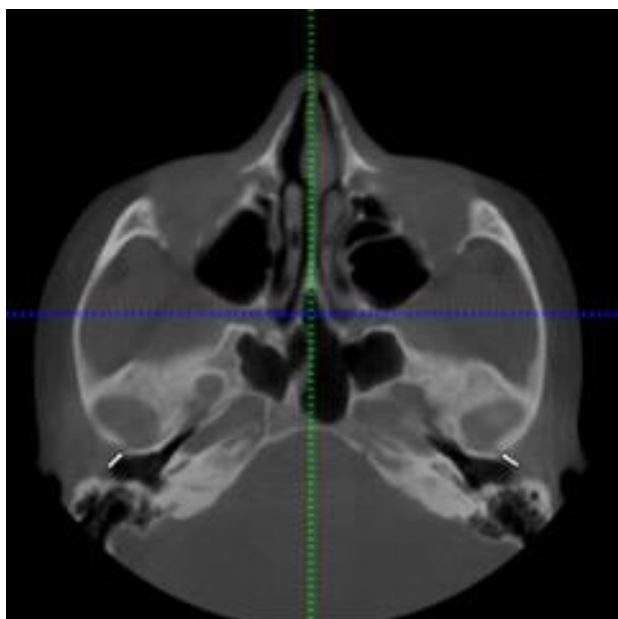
Axial CBCT image showing displaced fractures of EAC in right and left sides (white arrows)
